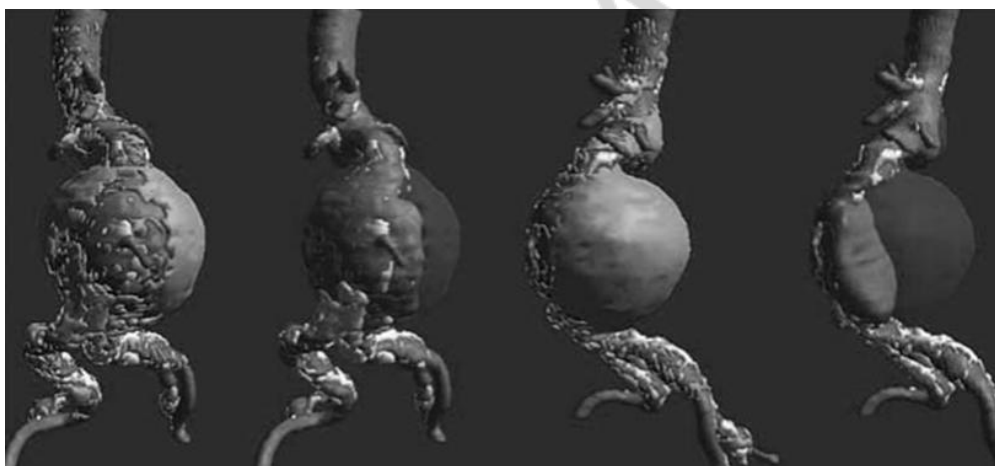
Three dimensional reconstructions of abdominal aorta aneurysm during CT angiography
